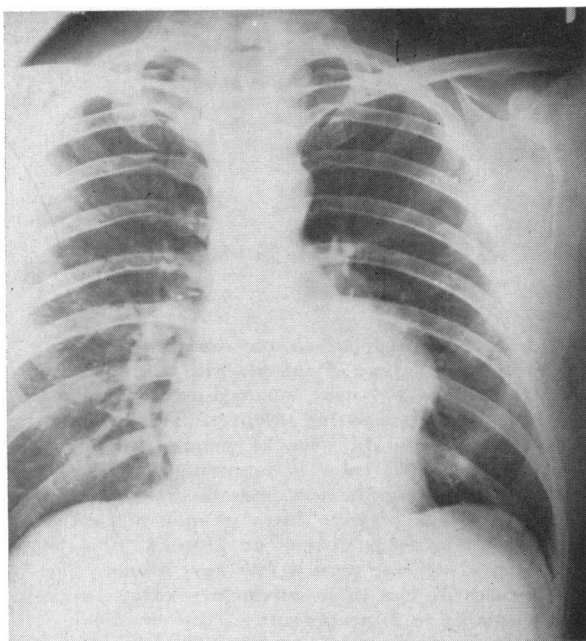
Anteroposterior roentgenogram of a patient with a large aneurysm of the left ventricle.
